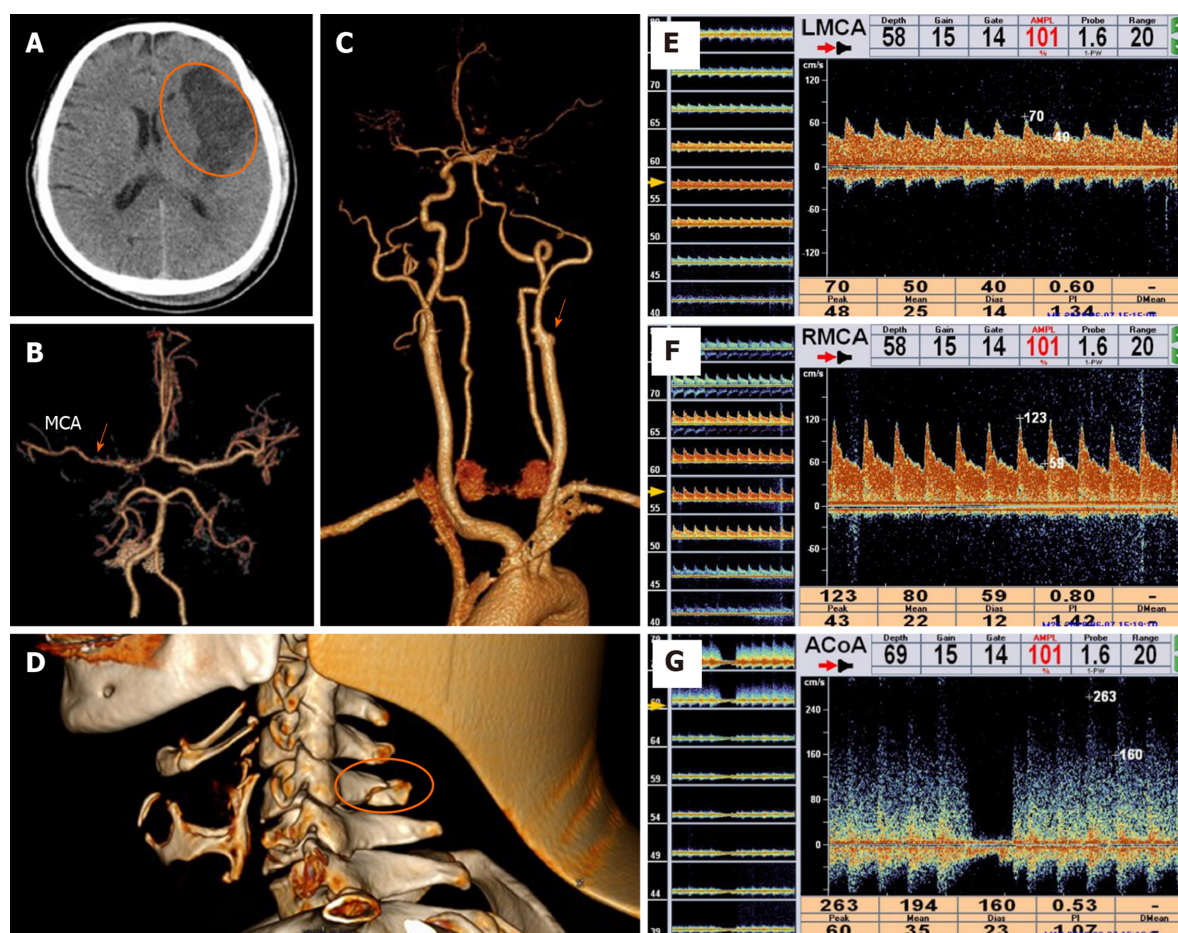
Imaging of case 3. A: Computed tomography (CT) revealed left frontotemporal infarction (ellipse); B: Head CT angiography revealed a thin middle cerebral artery (arrow); C: Cervical CT angiography revealed left internal carotid artery occlusion (arrow); D: A 3D-CT scan showed a cervical spinous process fracture (ellipse); E and F: Transcranial doppler showed asymmetry between the blood flow velocities of the two middle cerebral artery caused by left traumatic internal carotid artery dissection; G: When the right internal carotid artery was subjected to a neck compression test, the velocity of the anterior communicating artery rapidly decreased to zero and recovered when the compression was released. In E-G: FVd is the diastolic blood flow velocity, FVm is the mean blood flow velocity, FVs is the systolic blood flow velocity, and PI is the pulsatility index. MCA: Middle cerebral artery.
